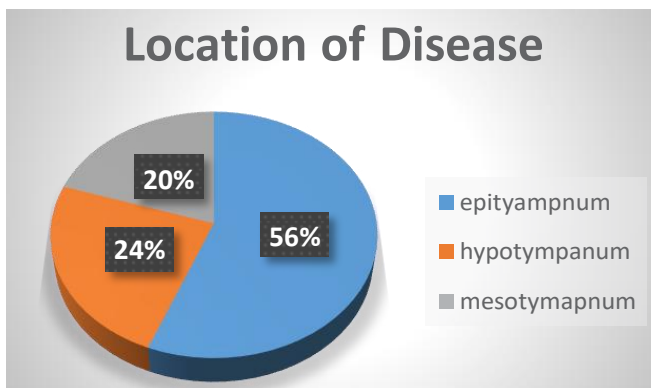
Location of disease in cases of otitis media on HRCT
